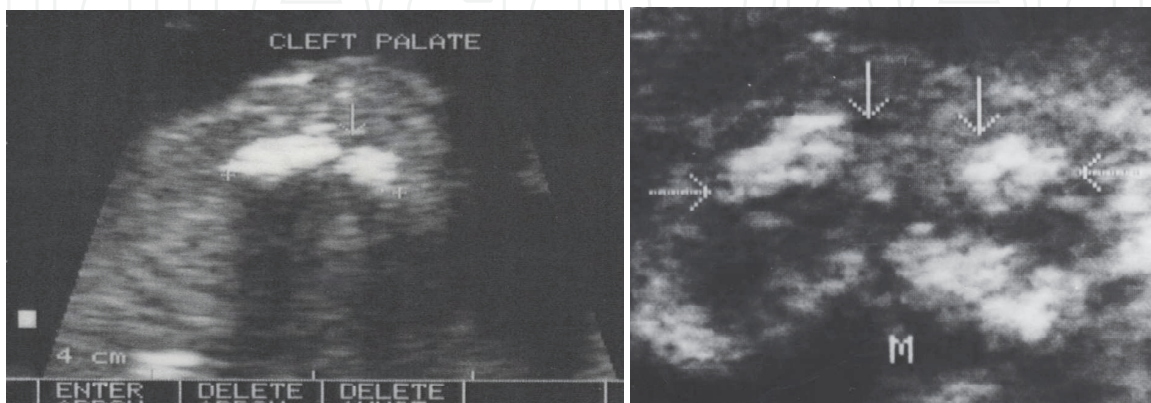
Sonographic pictures of cleft palate (15 & 23 weeks of gestation)
